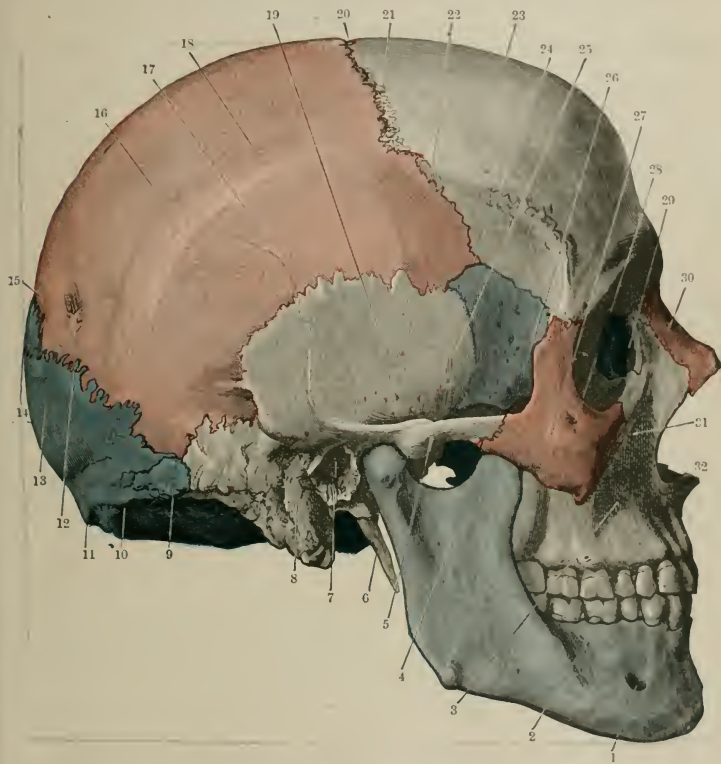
LATERAL ASPECT OF SKULL.
